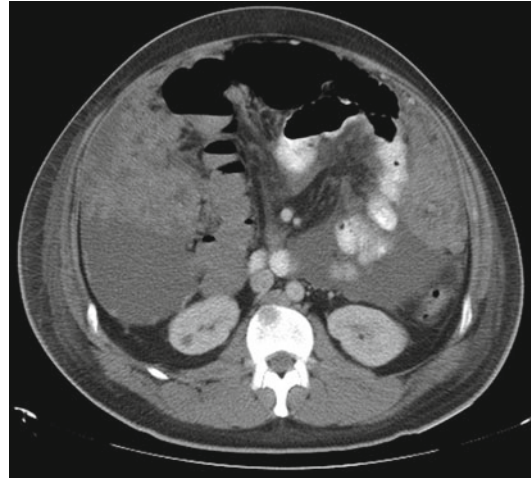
Peritoneal carcinomatosis. Axial CT abdomen demonstrating large volume ascites, omental caking and peritoneal disease in a patient with melanoma
